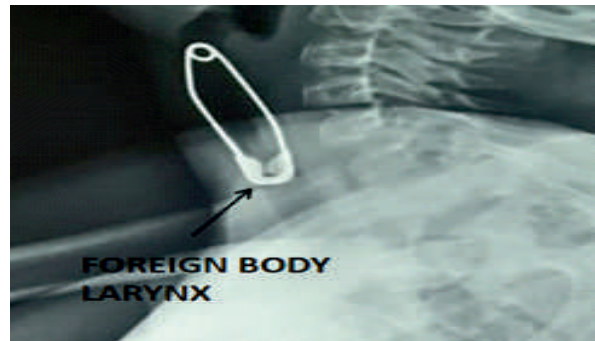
X-ray neck lateral view showing radio-opaque foreign body in the airway at level of C3-C6 vertebrae
